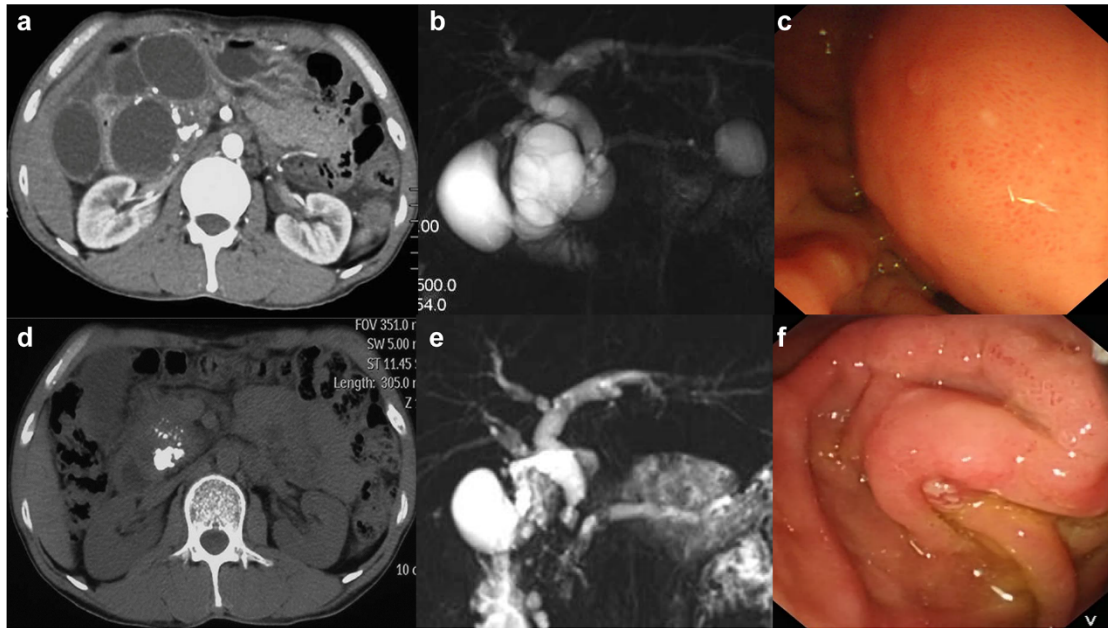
A and B. Computed tomography (CT) and magnetic resonance cholangiopancreatography (MRCP) suggestive of chronic pancreatitis and pancreatolithiasis, with multiple large cystic lesions in the head and tail of pancreas. C. During ERCP, the major papilla was compressed by a large bulging mass. D and E. Six months later, CT and MRCP showed a spontaneous resolution of most of the pancreatic cysts after pancreatic enzyme replacement treatment. F. The major papilla was easily identified.
